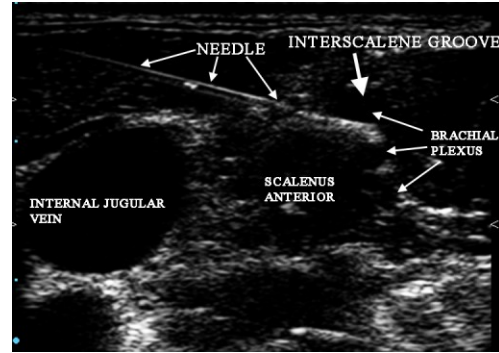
Sonogram of interscalene brachial plexus block prior to injection. Needle tip is seen between upper and middle trunks in interscalene groove. Anterior in plane approach
